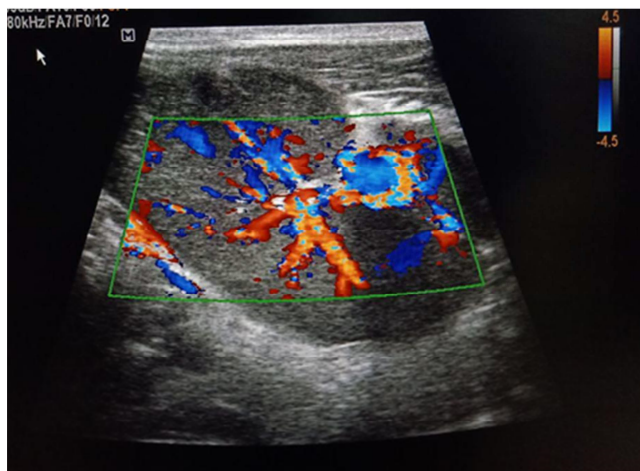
Colour Doppler ultrasound showing enlarged hypoechoic lymph node with cartwheel pattern of vascularity consistent with lymphomatous lymph node
